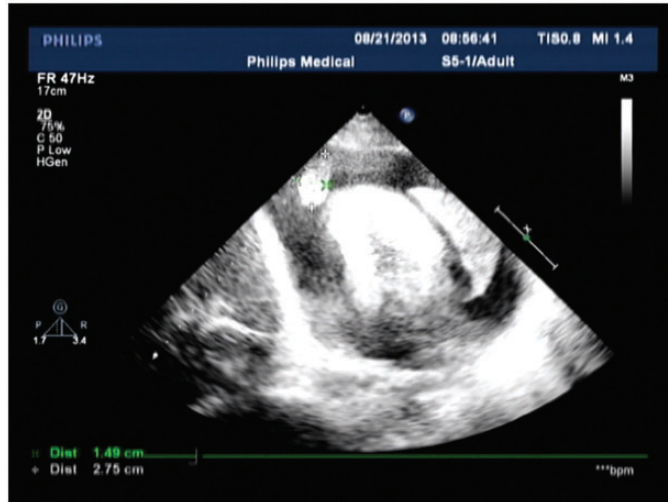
Echocardiographic finding on admission. Free-floating irregular masses in a large amount of pericardial effusion can be seen.
